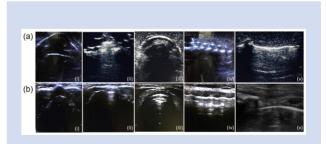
Collage of sonographs showing anatomical structures in the airway model (a) and a live subject (b). Axial view of the thyroid cartilage, cricothyroid membrane and cricoid cartilage are shown in columns (i), (ii), and (iii), respectively. Sagittal views of the trachea and cricothyroid membrane are shown in columns (iv) and (v), respectively.
